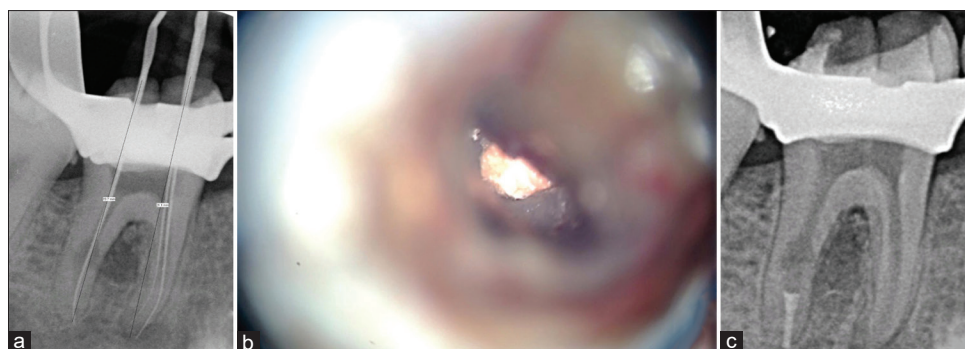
(a) Radiograph showing working length determination. (b) Magnified image of obturation of the apical part of the canal with GP. (c) Radiographic verification of the obturation of the apical part of the canal
